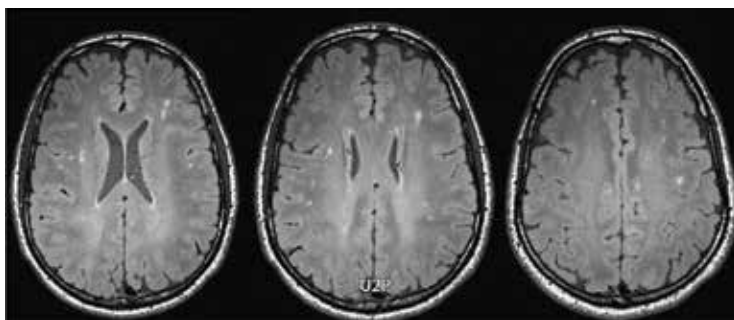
Axial FLAIR images demonstrating multiple subcortical WMHs in a U-2 pilot, without NDCS.
